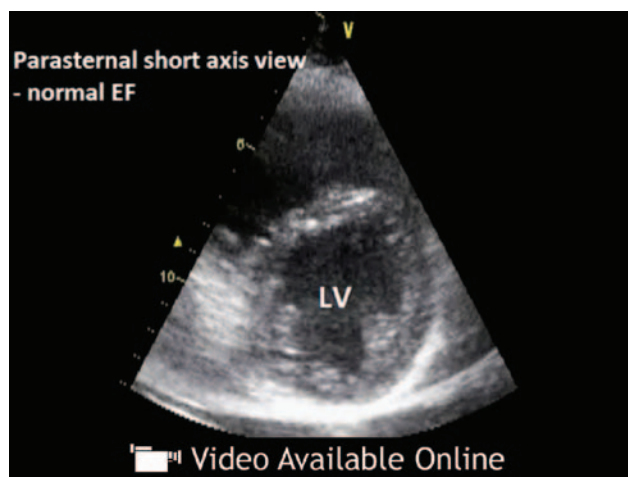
A, Parasternal long-axis view obtained at position 3. B, Parasternal short-axis view obtained at position 3. RA = right atrium; RV = right ventricle; LA = left atrium; LV = left ventricle; AO = aorta.
